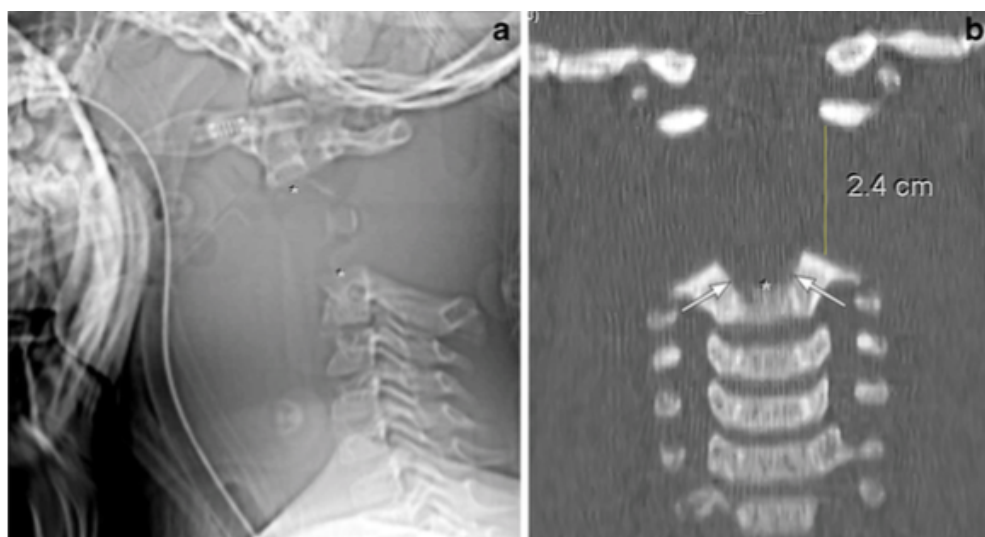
Type I subtype d fracture in Patient 3, a 4-year-old boy with fatal injury after motor vehicle crash. (a) Lateral scout (X-ray) and (b) coronal CT images show fractures of the right and left odontoneural (arrows) and the odontocentral synchondroses (*) with 7.2 mm anterior displacement, 14 deg anterior angulation and marked, 2.4 cm, distraction of the odontoid segment. Brain CT (not shown) revealed massive subarachnoid hemorrhage.
